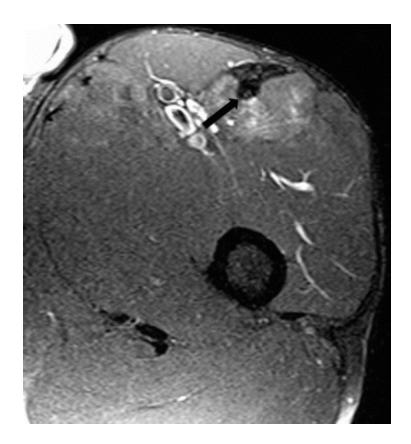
A 32-year-old female athlete with fibrous encasement of the deep rectus femoris tendon three months after injury. Axial fat-suppressed T2-weighted MRI shows thickened and hypointense superficial and deep tendons (*arrow*)
